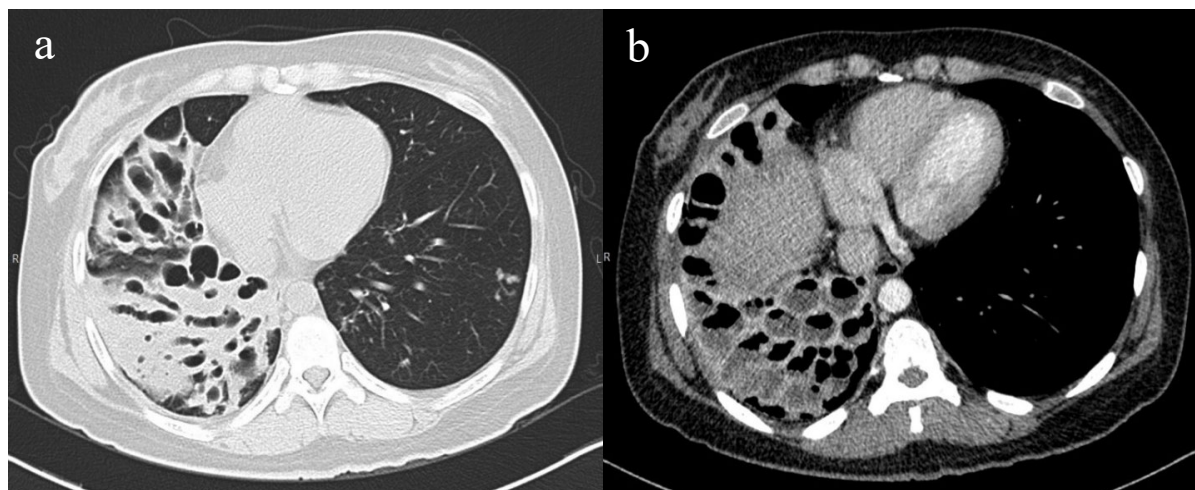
Axial contrast-enhanced CT thorax in (a) lung window and (b) mediastinal window demonstrate multiple cystic bronchiectasis in the right middle and lower lobes. (b) Air fluid level is observed within most of these saccular dilations.
